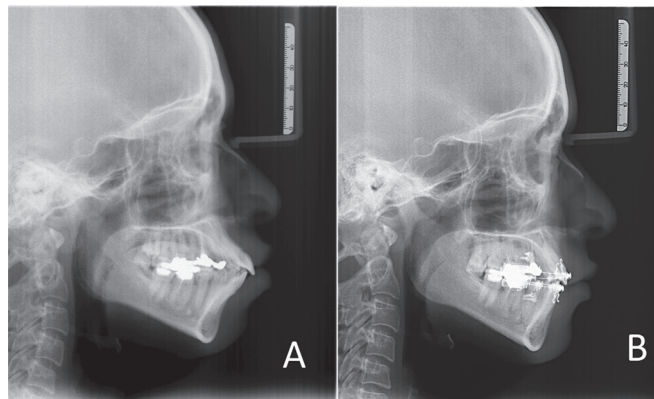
Lateral cephalometric radiographs (A) Pre-retraction (B) Post-retraction
